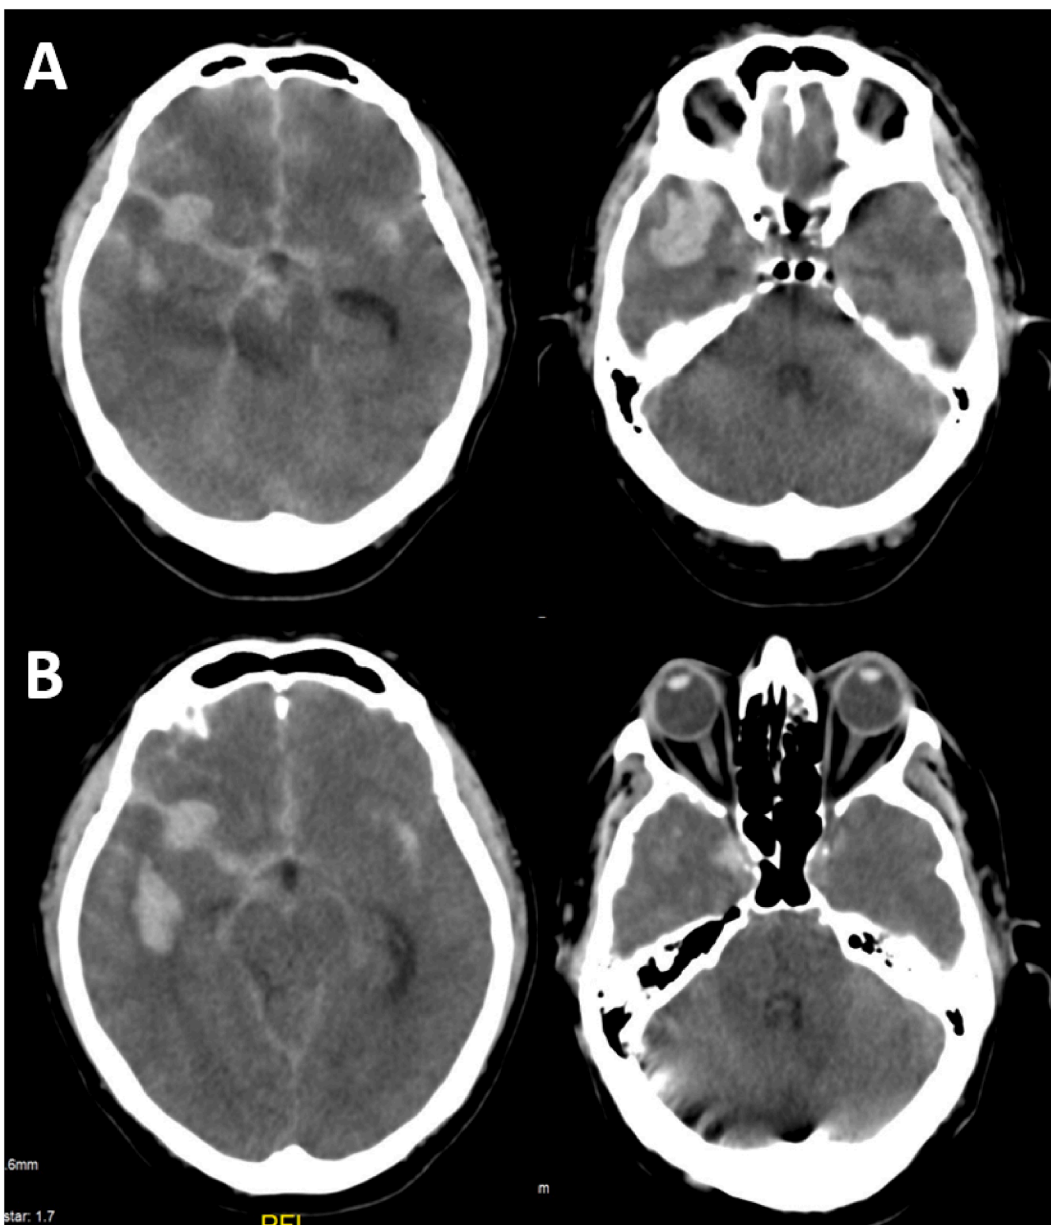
Case 3. Brain CT scan showing a Fisher IV subarachnoid hemorrhage of aneurysmal origin (right middle cerebral artery), right temporal intraparenchymal hematoma (A) that generates mass effect with 4.8 mm midline shift and no ischemic lesions. (B) 3-hour later, a new CT scan showed an ischemic stroke in the right cerebellar hemisphere and compression of the cistern and brainstem.
